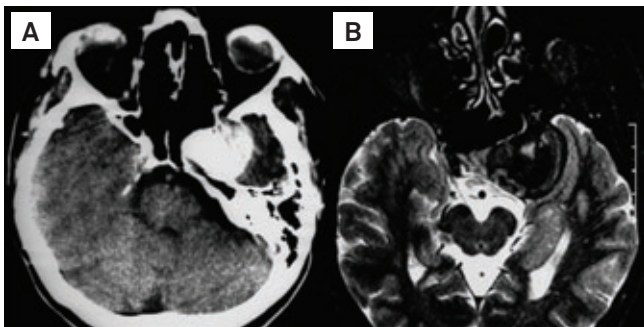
(A) The computed tomography scan showing a high-density parasellar round lesion extending to the left middle cranial fossa. It was first misdiagnosed as a brain tumor. (B) Axial T2 weighted image revealing the giant thrombosed aneurysm.
